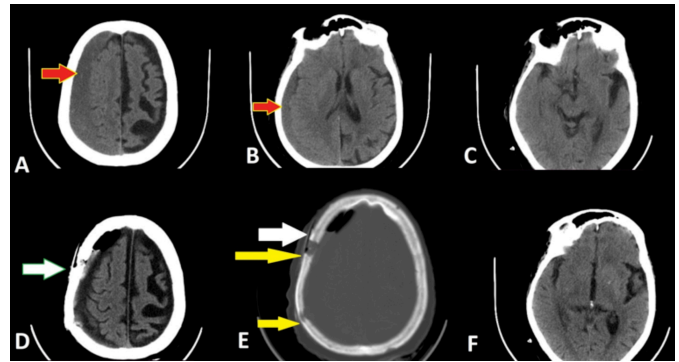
Sixty-five year old with history of head injury 14 days ago, presented with headaches and altered mental status. (A, B, C) Preoperative CT brain without contrast. Red arrow points to right-sided hypo to iso-dense collection in the subdural space. (D, E) Postoperative CT brain shows reduced collection. White arrows point to position of subgaleal drain overlying burr-holes. Yellow arrows point to the two burr-holes used forevacuation of hematoma. There is mild pneumocephalus evident in the frontal region that was treated conservatively. (F) CT brain performed at 14 days post-op. shows total resolution of hematoma and mass effect. Effacement of sulci noted in previous images is notably absent.
